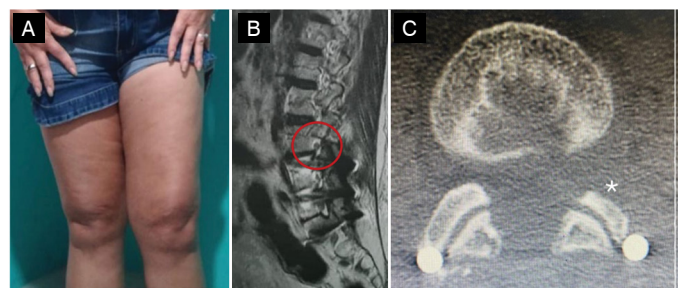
Clinical aspect of the lower limbs, with increased volume and redness of the left lower limb (A); sagittal MRI section (B) and axial CT section (C) post-operative, showing improvement of the left L3-L4 foraminal space (red circle and asterisk).
